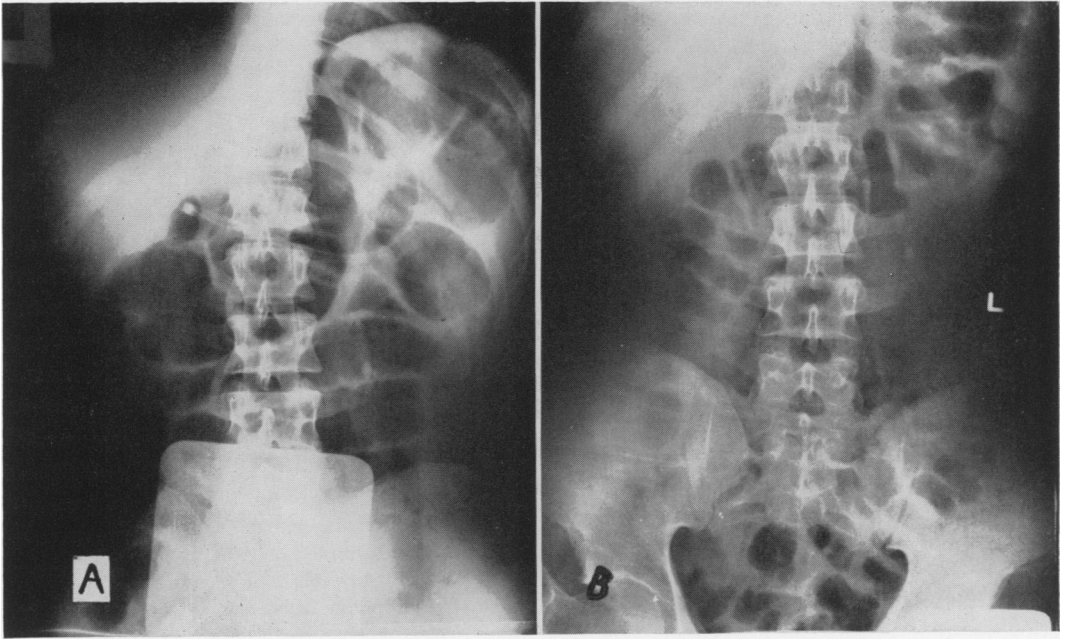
Abdominal x-rays of Patient K. E. with reflex ileus secondary to renal stone and colic. A. X-ray taken upon starting gastro-intestinal pacing. Note distended bowel and position of the electrodes. No suction was utilized. Oral intake was allowed. Left renal calculus is shown. B. Twelve hours later. Patient passed flatus and feces. Film shows decreased gas and distention.
